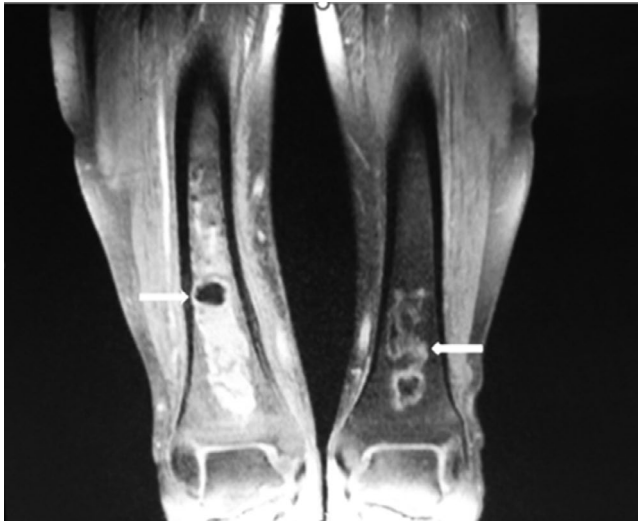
Large areas of necrosis in both tibias on magnetic resonance imaging
